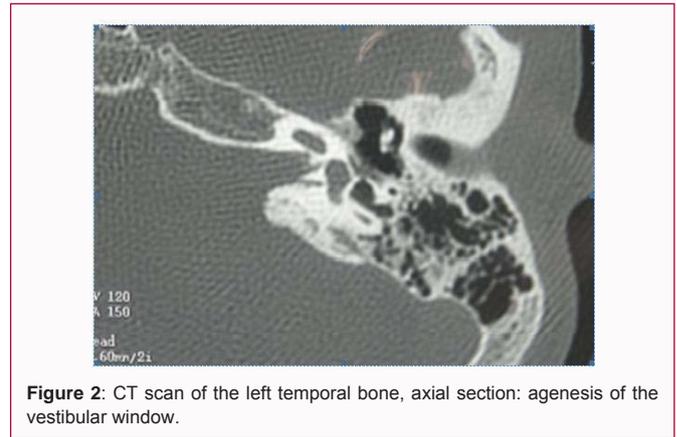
CT scan of the left temporal bone, axial section: agenesis of the vestibular window.
